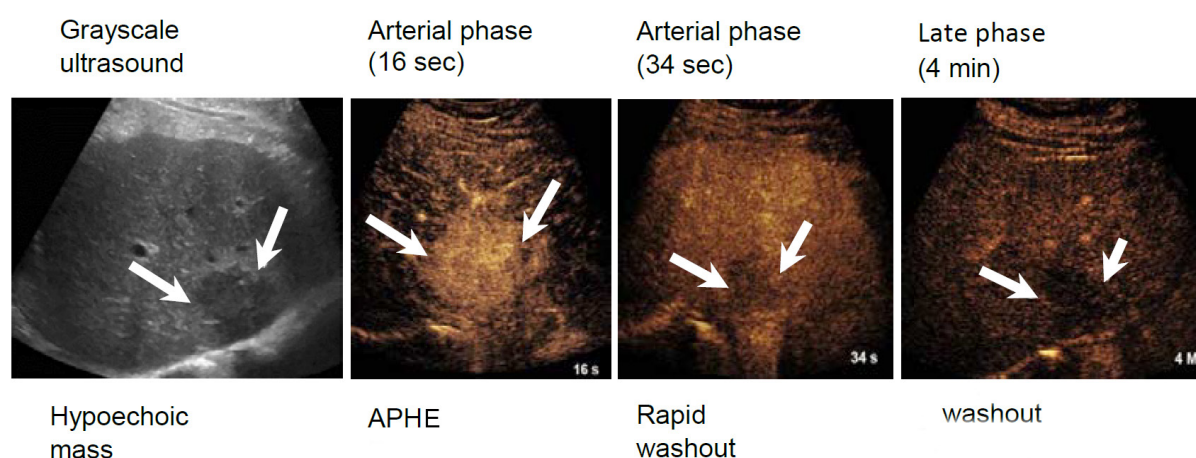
Example case of a LR-M nodule. 78-year-old male with HBV and a growing nodule on MRI, approximately 3 cm, previously diagnosed as a hemangioma on MRI. CEUS imaging demonstrated arterial phase hyperenhancement at 16 s followed by almost immediate washout by 34 s. Biopsy showed the mass to be intrahepatic cholangiocarcinoma (image reproduced with permission from the ACR). MRI: magnetic resonance imaging; HBV: hepatitis B virus; CEUS: contrast-enhanced ultrasound; ACR: American College of Radiology
